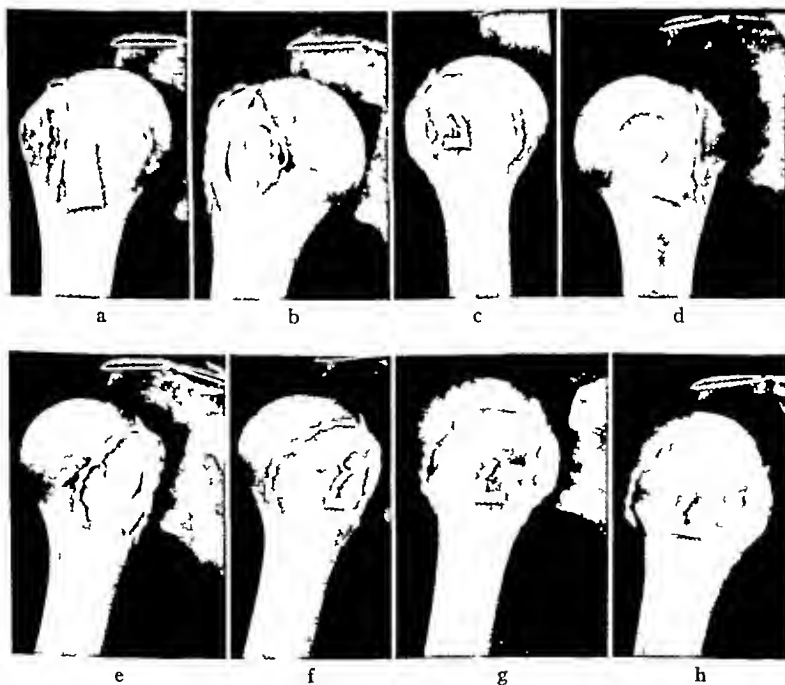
Skeletal roentgen studies beginning in external rotation and gradually externally rotating humerus until complete circle is rotated a, b, Reveal greater tuberosity in profile view f, g, h, Reveal the lateroposterior head of the humerus in profile view
